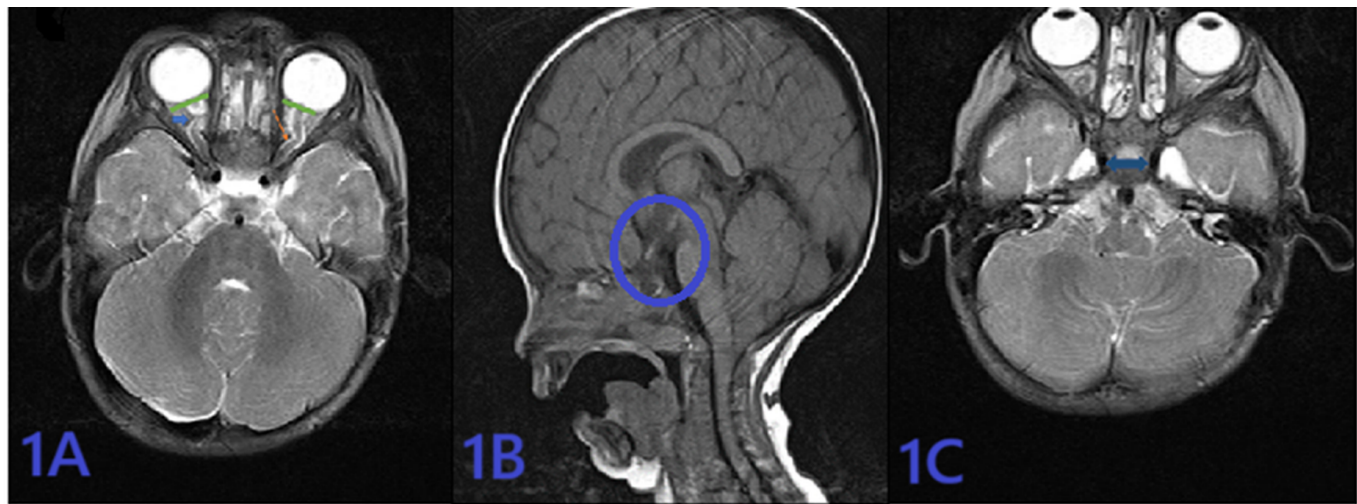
Brain MRI Findings in Patients with PTCS; 1A: Axial T2-weighted images showing bilateral optic nerve tortuosity, increased perineural fluid, and flattening/bulging of the optic disc. 1B: Sagittal T1-weighted images showing an empty sella appearance with the suprasellar cistern extending toward the pituitary. 1C: Axial T2-weighted images demonstrating bilateral enlargement of Meckel's cave spaces.
